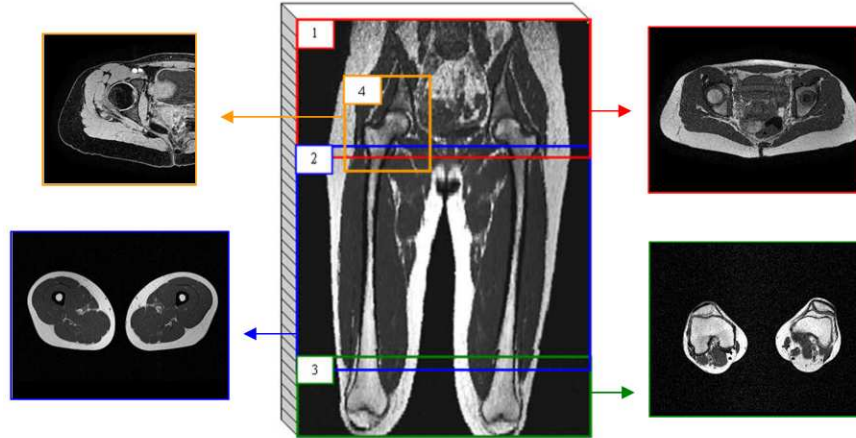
Static MRI protocol for the hip
